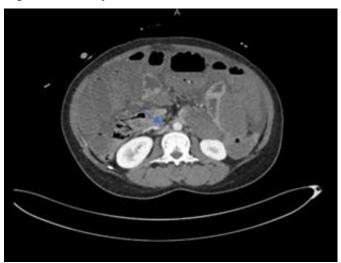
CT abdo/pelvis showing There is a significant narrowing and abrupt cut off of the superior mesenteric artery on arterial phase with significant narrowing at this level on venous phase. Appearances are highly concerning for superior mesenteric artery thrombosis.
